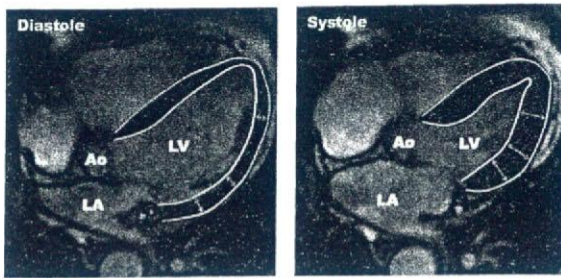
Normal cardiac contraction and wall-thickening effect obtained at a healthy subject by MRI.
